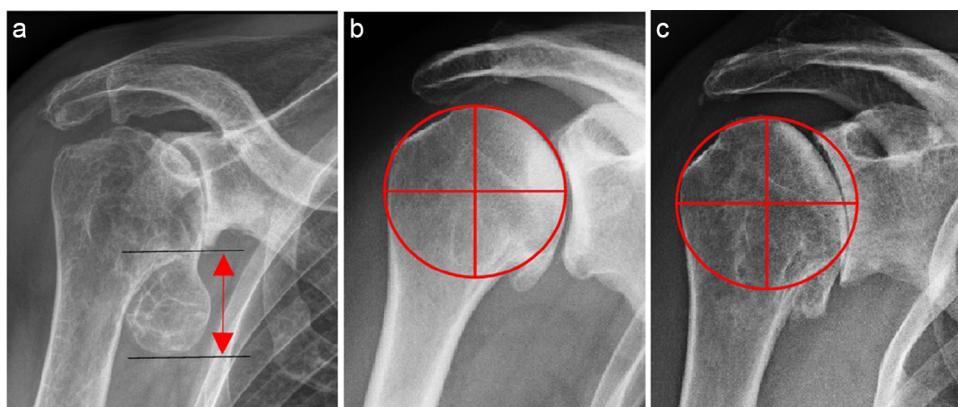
Humeral head measurements in the coronal plane on anterior-posterior radiographs. (A) Measuring the caudal humeral osteophyte on anterior-posterior image. (B) Spherical head shape with projection of the best-fitting circle onto the cortical boundaries of the humeral head. (C) Aspherical head shape. Cortical boundaries on the articular side of the humeral head are not within the confines of the best-fitting circle.
